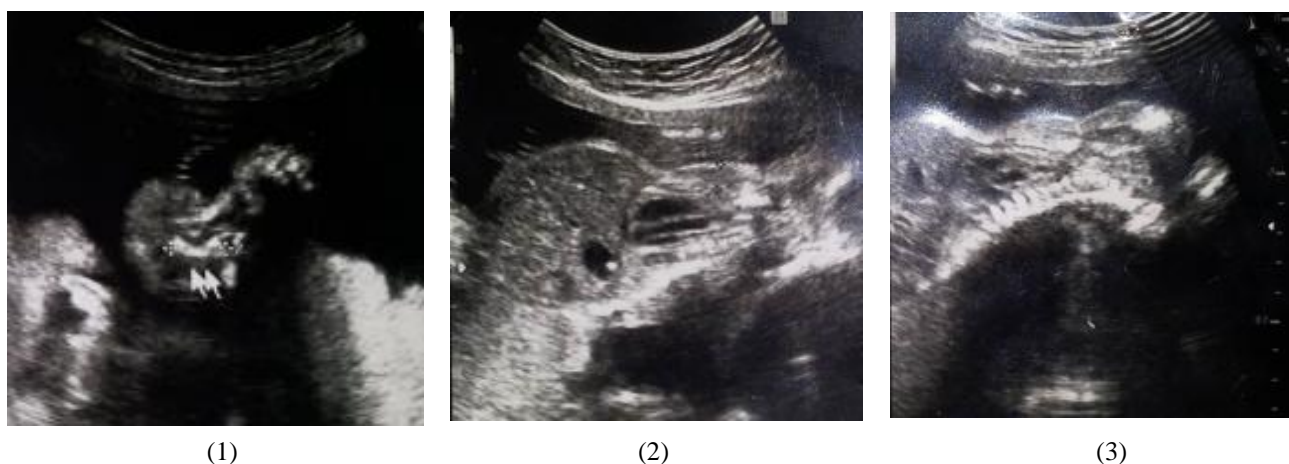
Antenatal 2D ultrasound images of the fetus showing short and curved femur, (1) evidence of polyhydramnios, (2) tubular shape narrow chest deformity and (3) hyperextended cervical spines
